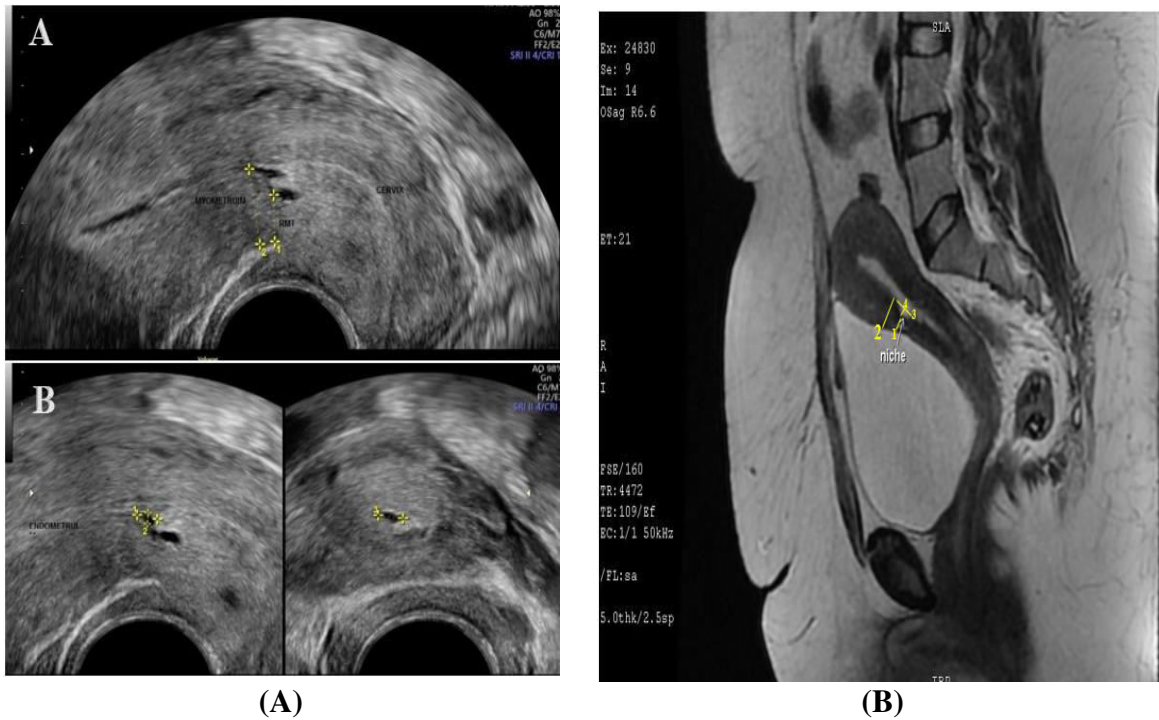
(A) TVUS show TVUS with anechoic cystic area at the anterior uterine wall at the isthmus. Niche is detected A) 1. residual myometrial thickness: 6.8mm, 2.AMT:11mm B) 1. Length: 3.5mm, 2. Depth: 1.8mm, 3. Width: 4.2mm, (B) MRI revealed midsagittal T2 WI with myometrium defect at the site of previous scar Niche is detected 1. RMT: 7.5mm , 2.AMT:12mm, 3.Length: 4.2mm 4.Depth: 2.3mm
